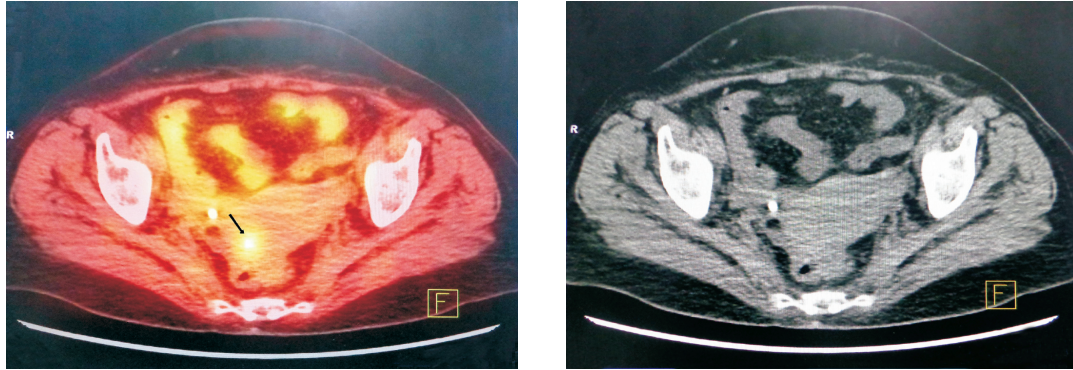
PET-CT showing uptake in the cervix
